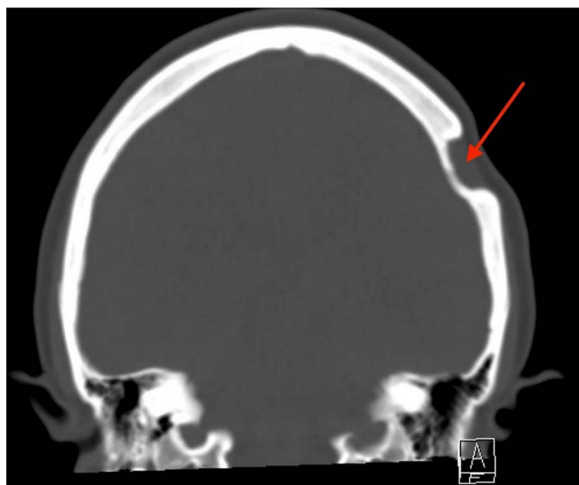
Coronal CT scan (pre-operative) showing a defect (arrow) in the left parietal bone.
